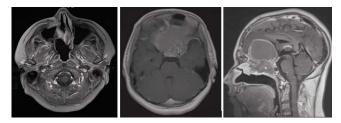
Follow-up post-op MRI showing interval increase in size of infiltrative solid cum cystic neoplastic lesion at the floor of anterior cranial fossa.
